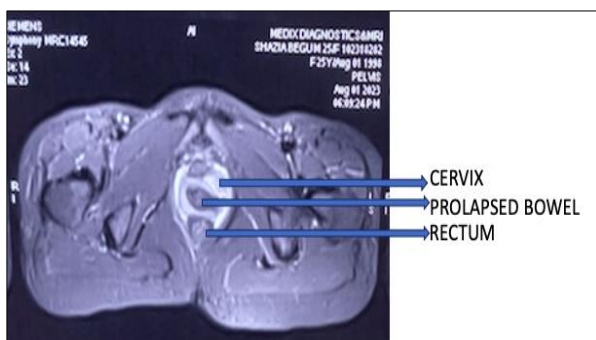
MRI (coronal view) showing prolapsed bowel.
